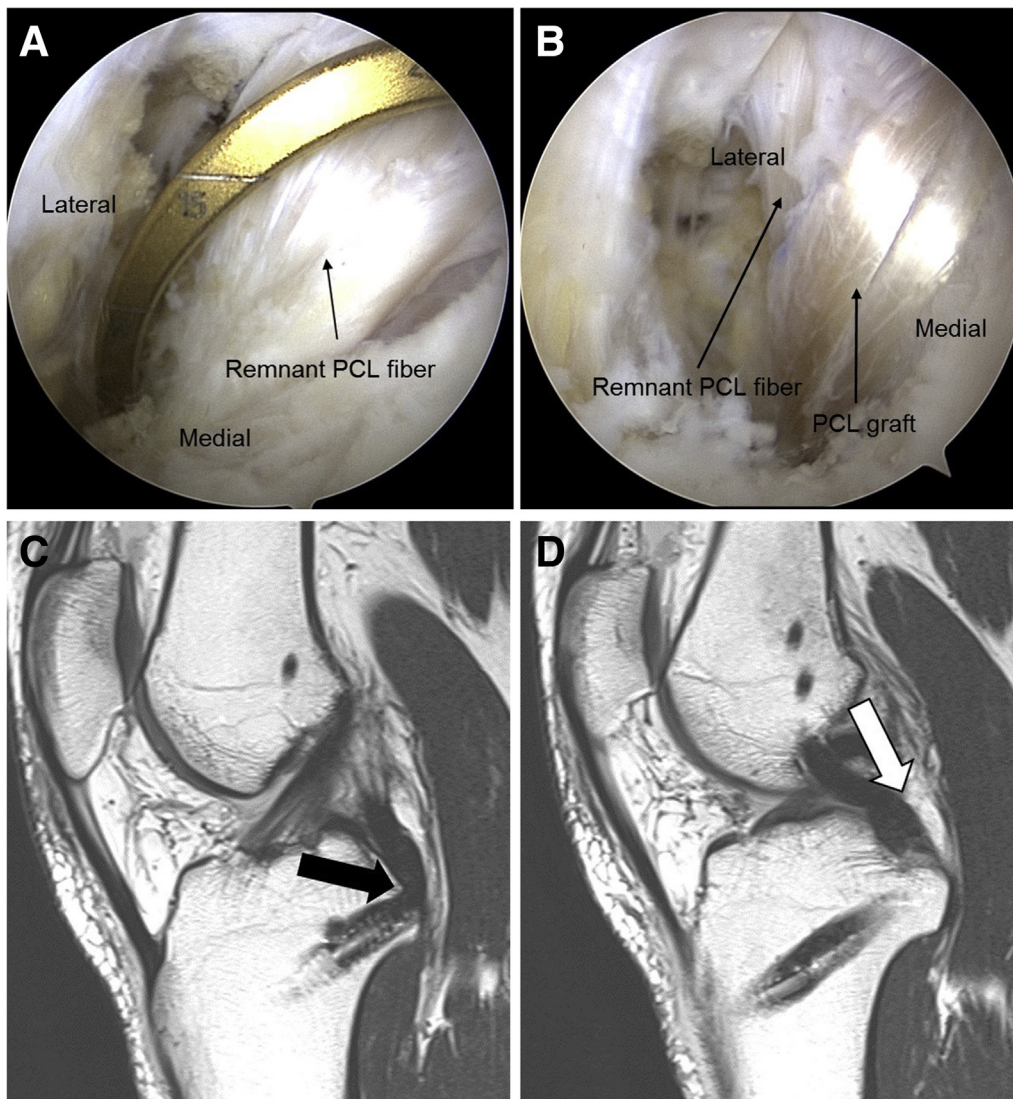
23-year-old man underwent posterior cruciate ligament (PCL) reconstruction on the left knee, and magnetic resonance imaging (MRI) was obtained at 12 months after PCL reconstruction. (A) During PCL reconstruction, the guide tip was advanced to ~15 to 20 mm below the joint line with excellent visualization. (B) Remnant PCL fiber is mostly preserved. (C and D) Post-operative MRI scans of left knee at 1-year follow-up reveal complete healing without the killer-turn effect (black arrow) and PCL graft forming a broad cross-sectional area (white arrow).
